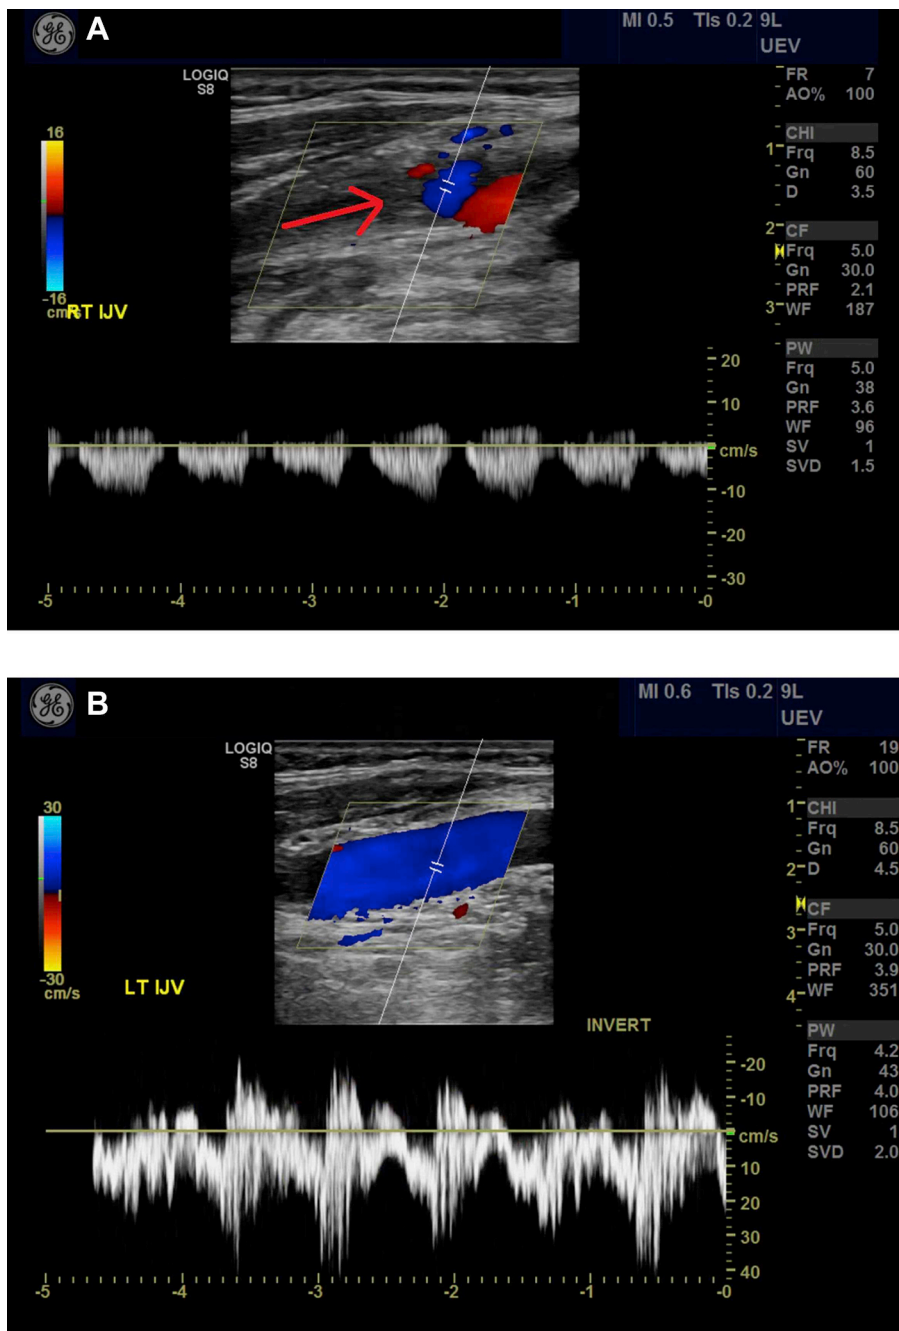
Neck Ultrasound A. Right internal jugular vein with near-occlusion (red arrow). B. Left internal jugular vein with normal flow. (For interpretation of the references to color in this figure legend, the reader is referred to the Web version of this article.)
